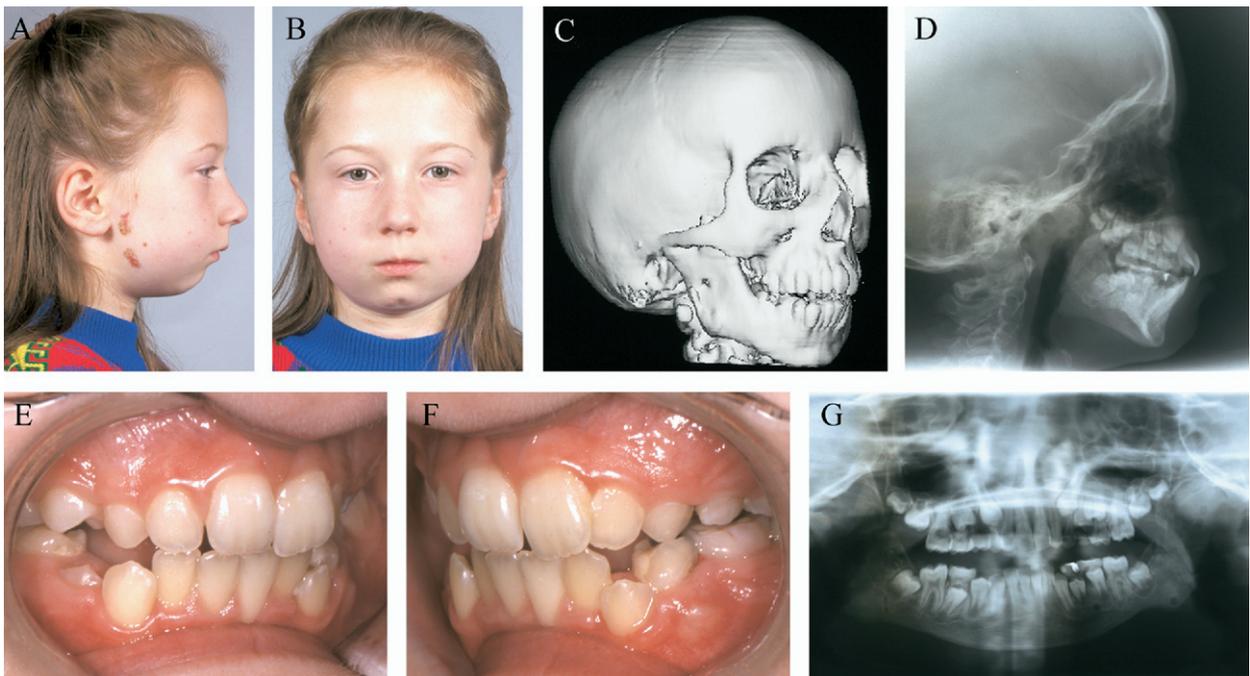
Postdistraktion records at 10 years 1 month: A and B, facial photographs; C, 3-dimensional computed tomography scan; D, cephalometric radiograph; E and F, intraoral photographs; G, panoramic radiograph.
